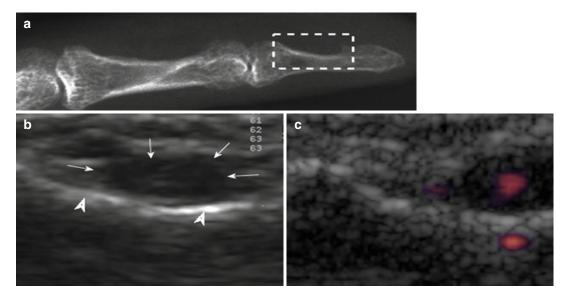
(a) Lateral radiograph of the left fifth digit in a 16 year old female with a tender lump within the dorsal aspect of her finger tip; showing early bony scalloping along the flexor surface of the distal phalanx. (b) High resolution ultrasound focussing on the area outlined by
